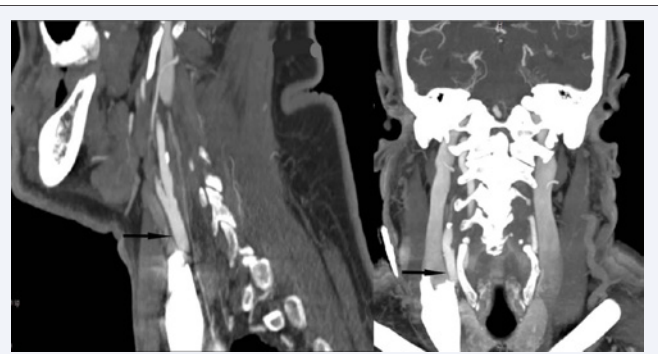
A 1-month CTA follow-up.
